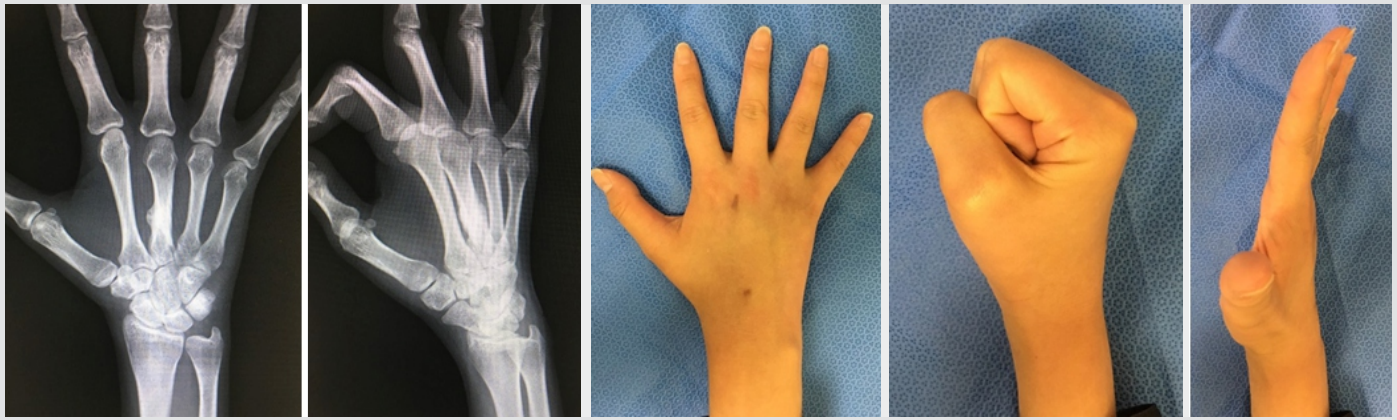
Plain radiography and range of motion after 12 months. Bone fusion had been acquired on plain radiography (a) frontal view, (b) oblique view. The wound scar on the dorsum of the hand was not noticeable (c), and no restriction of flexion (d) or extension (e) of the MP joint was noted.
